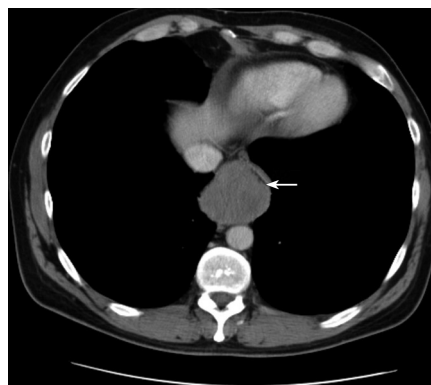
CT scan of chest highlighting the large distal esophageal mass. Note the impressive constriction of the esophageal lumen (arrow).
